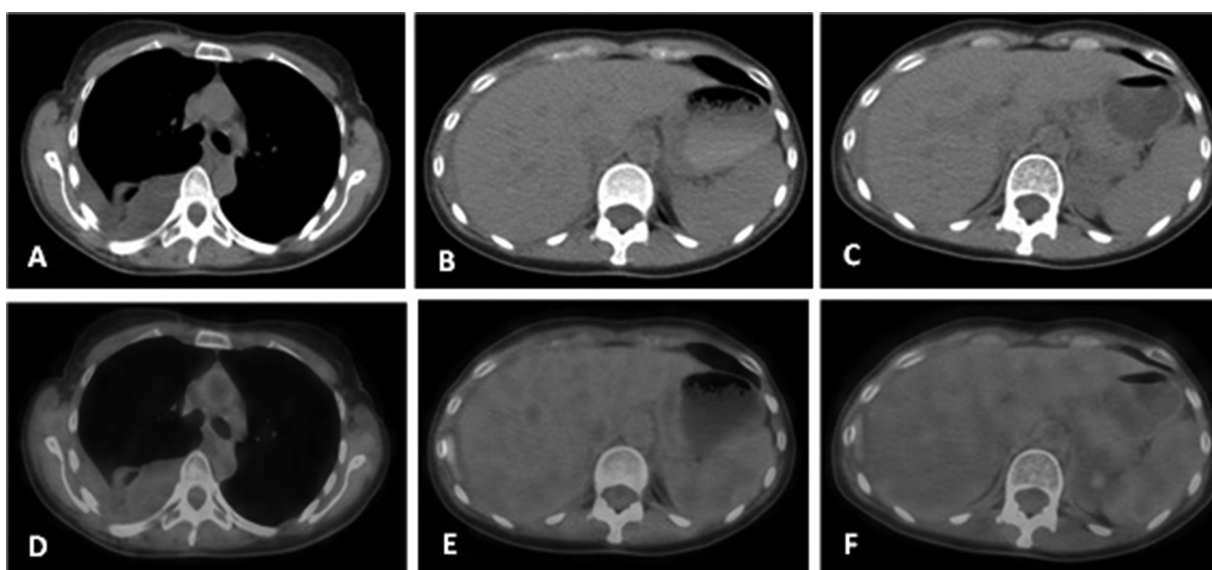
(A–F). PET scan and Chest CT scan showing slight uptake of fluor-18-fluorodesoxyglucose (FDG) in pleural nodules and pleural effusion (SUV max.=1.22); small area of pleural thickening between right liver lobe and 9th right rib with more intense FDG uptake (SUV max.=4.74); no other relevant alterations.
